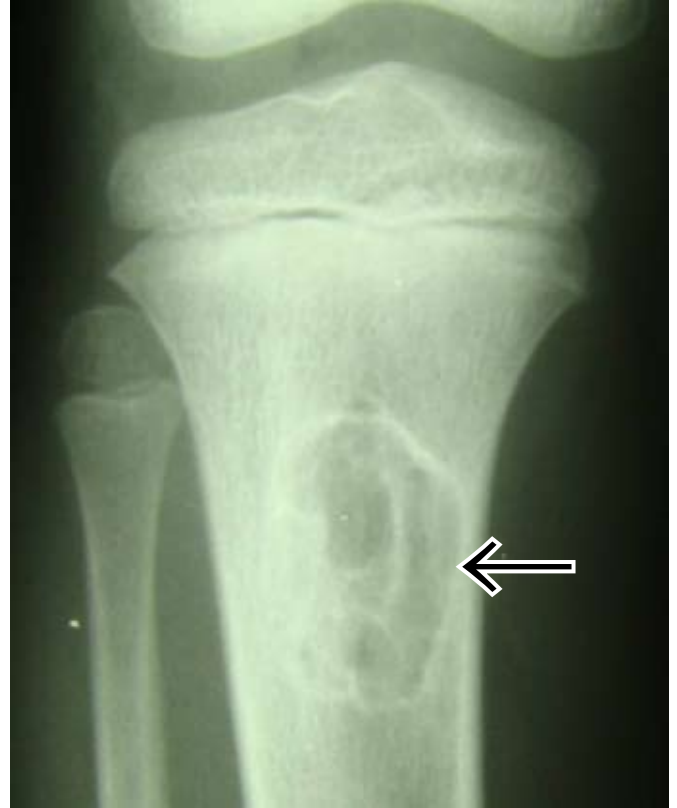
Anteroposterior radiograph of the knee with intraosseous neurofibroma of the proximal tibia.
